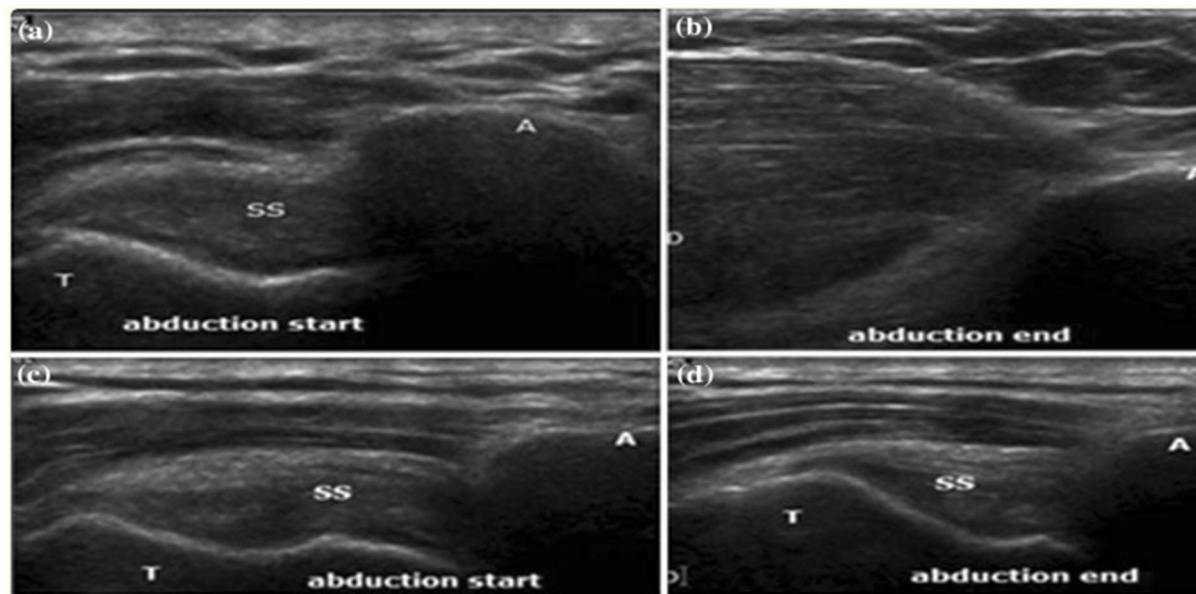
Dynamic Ultrasound Imaging of Shoulder Abduction (Sonogram a, b reveals normal abduction showing complete passage of tendon and subacromial-subdeltoid bursa beneath the acromion in a control subject. Sonogram c, d in adhesive capsulitis showing incomplete passage of supraspinatus (SS) tendon beneath the acromion (A). T greater tuberosity)*
